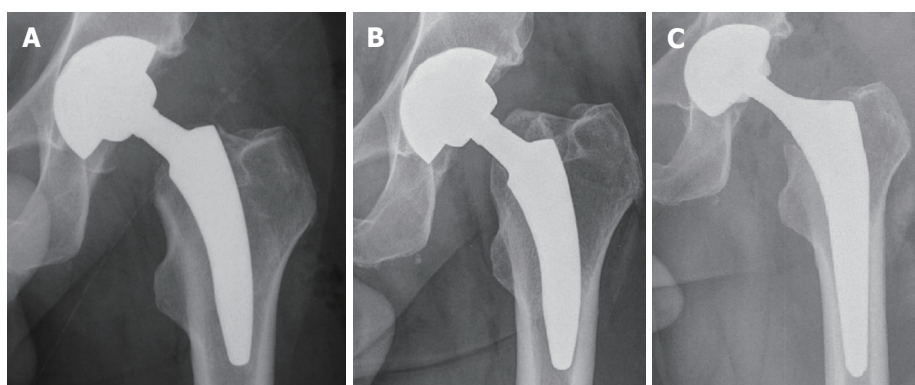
Exemplary X-ray of one of the two cases with a symptomatic subsidence. A: Postoperative X-ray; B: Subsidence of 15 mm twelve months after surgery; C: X-ray of the one-stage revision to a conventional stem.
